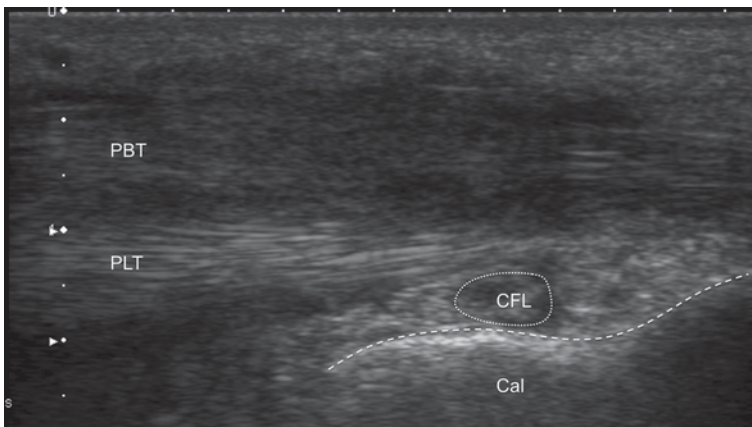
Longitudinal scan of the peroneus tendons below the lateral malleolus. The patient was complaining of pain behind the lateral ankle exacerbated by activities. Ultrasound examination shows normal structure of peroneus longus tendon (*PLT*) and hypoechoic, blurred structure of the peroneus brevis tendon (*PBT*). Diagnosis: peroneus brevis tendonitis. *CFL* calcaneofibular ligament, *Cal* calcaneus
